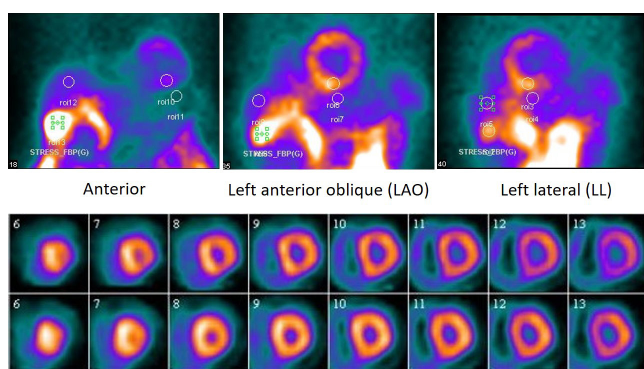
Raw data images of myocardial perfusion scan in anterior, LAO and left lateral views (top row, from left to right) and SPECT short axis images (bottom row) used in qualitative assessment of upper abdominal artifact. The regions of interest (ROIs) used in measuring the mean count activity at inferior wall, right hepatic lobe, gallbladder and intestinal loop adjacent to myocardium obtained from each view and then calculating the activity ratio between myocardium and the rest organs (modified from Grüning, *et al*¹⁰, Boz, *et al*¹¹ and Hara, *et al*¹²)
